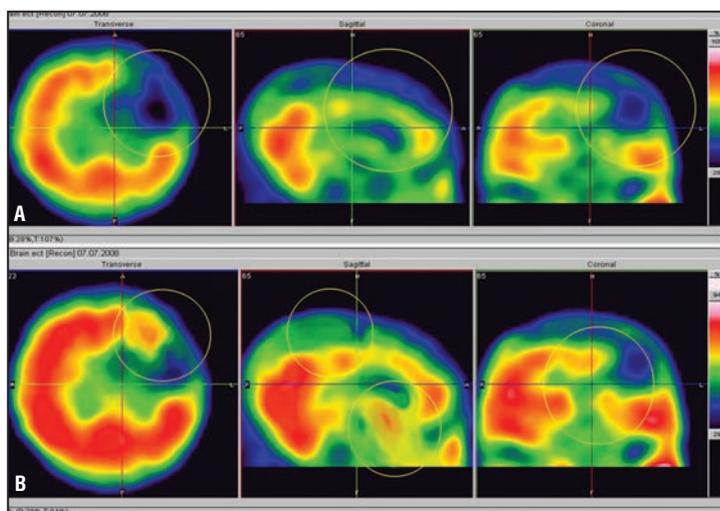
Increase of cerebral perfusion and regression of scintigraphic signs of focal ischaemia of cerebral tissue in a patient with ischaemic stroke in the right temporoparietal area before (A) and after (B) surgical treatment. Conventional designations: Red colour – normal distribution of the RPH, blue colour – zone of ischaemia.
